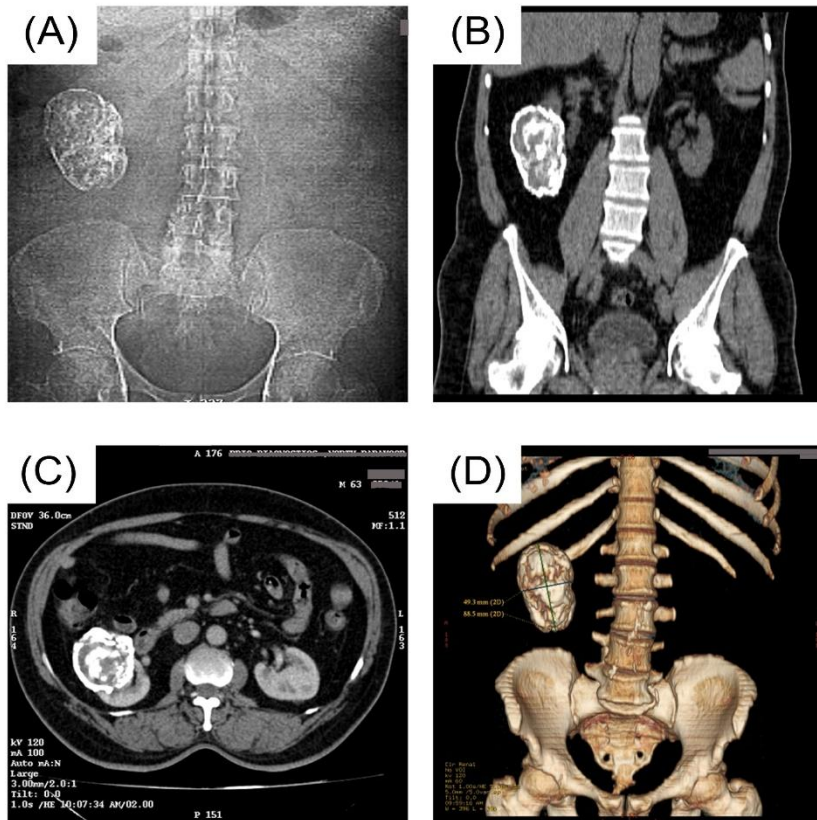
Panel A-CT topogram showing radio opaque right renal mass, Panel B,C-CT sections showing right renal mass with extensive calcification, Panel D-reconstructed CT image of the tumor
